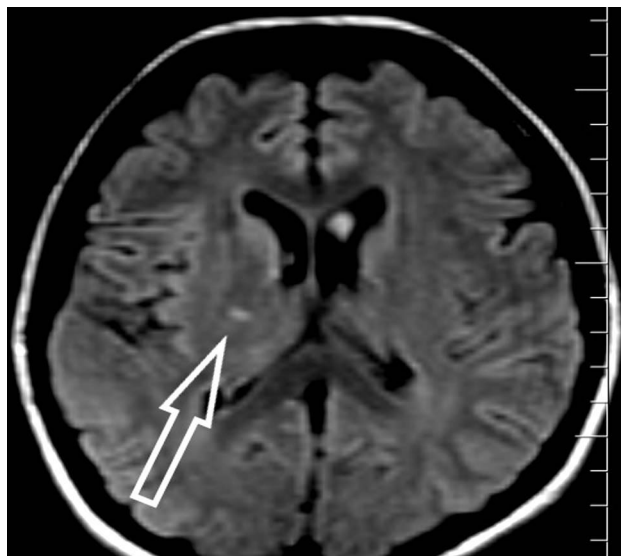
FLAIR sequence compatible with subacute infarction involving the ventral posterolateral nucleus area of the right thalamus.
